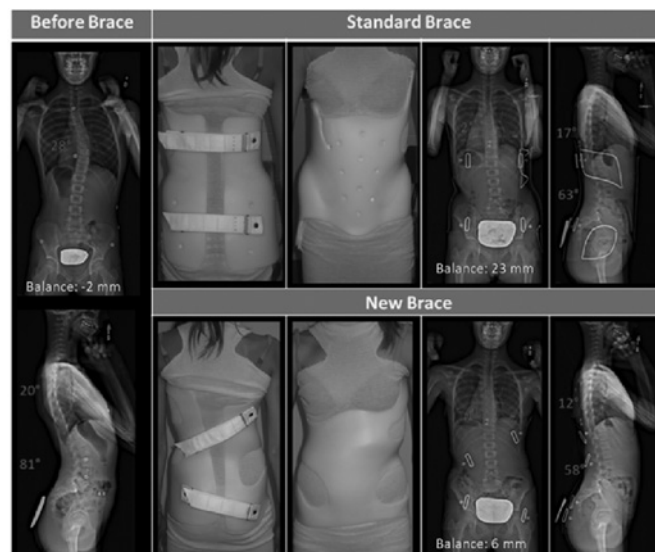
Radiographic results for a patient before bracing (Initial), with the STDBrace and with the NewBrace and the resulting spinal shape in the postero-anterior and lateral views
